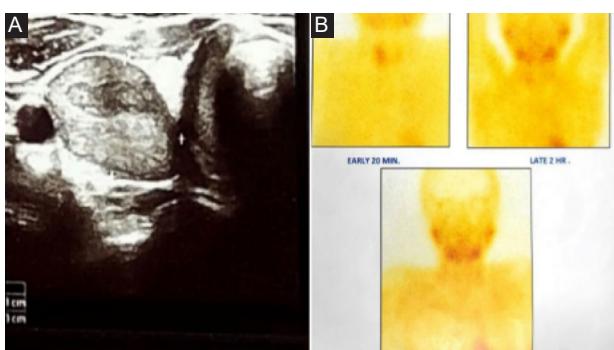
(A) Ultrasound of neck showing parathyroid lesion. (B) Sestamibi showing no tracer uptake in the delayed phase.
